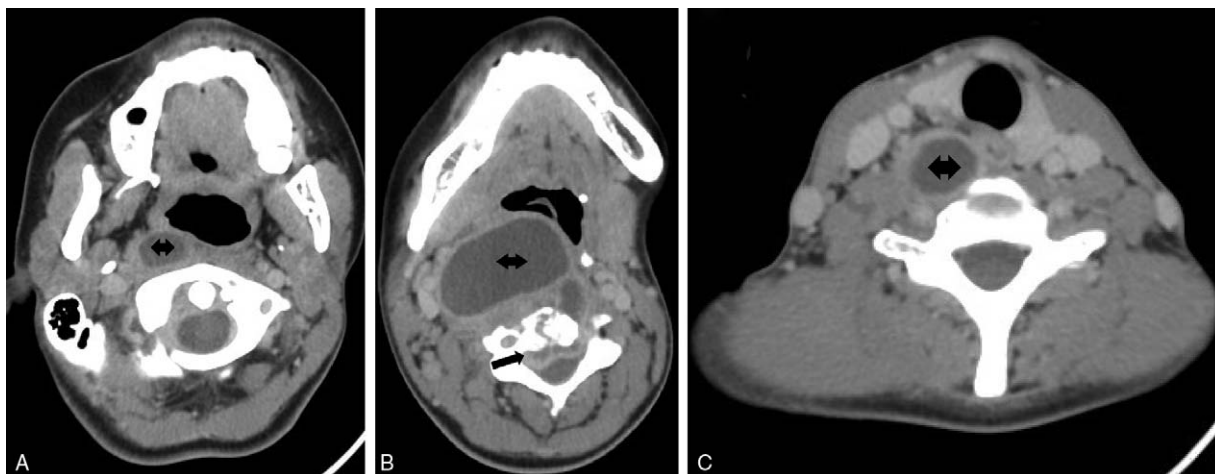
A, B, C, Axial computed tomography (CT) scan of the neck showed retropharyngeal abscess (double-ended black arrow) extending to the prevertebral space and epidural space of the spinal canal (black arrow), with destruction of the vertebral body and narrowing airway.
